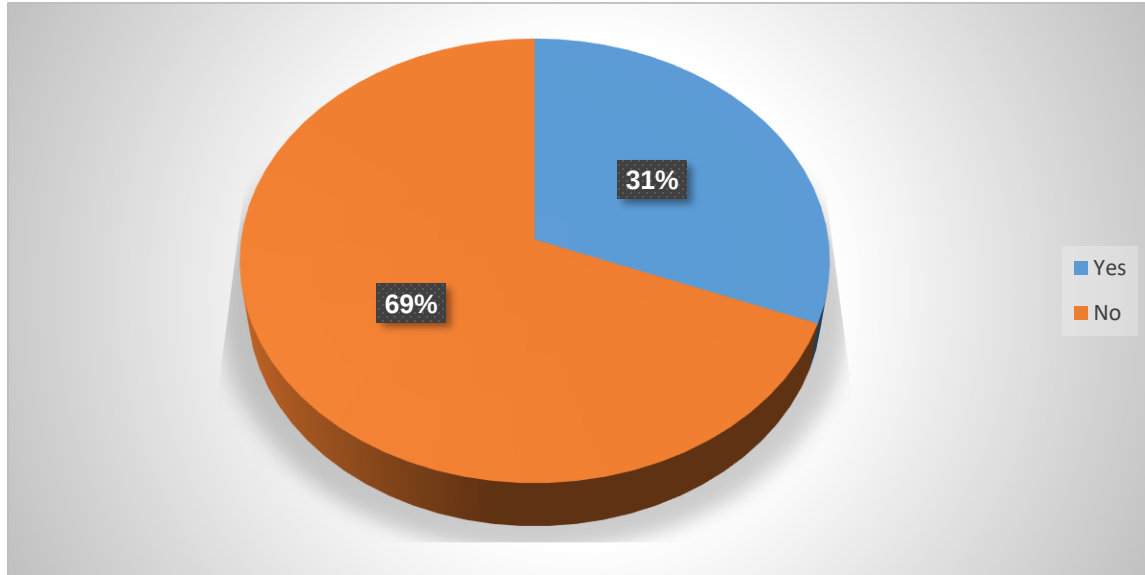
Radiographers' involvement in adult trauma CXR image interpretation
